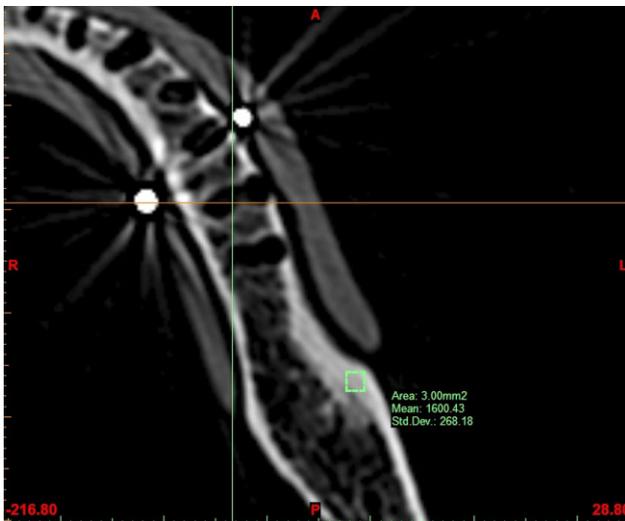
Determination of cortical bone computed tomography gray density values (Hounsfield unit [HU]). It should be noted that the coordinates of the drawn square are the same as in Figure 7 (−216.80, 28.80). The mean gray density value recorded was 1,600.43 HU.
